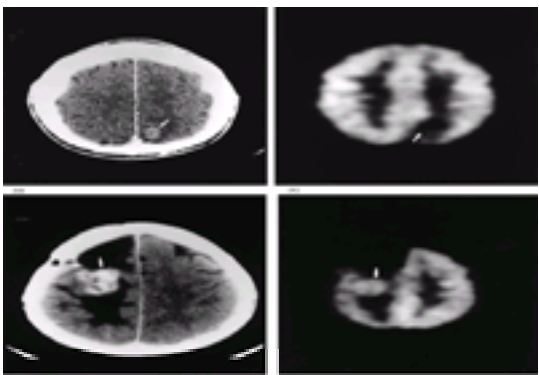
(a) Anatomic study showing an enhancing abnormality in the left occipital area (arrow). (b) FDG-PET image showing a hypometabolic lesion (arrow) corresponding to the anatomic abnormality; this is a low-grade astrocytoma. (c) Anatomic study showing an enhancing lesion in the right frontal area (arrow). (d) FDG-PET image shows a hypermetabolic lesion (arrow) consistent with a high-grade recurrence of glioblastoma multiforme in the same area.
